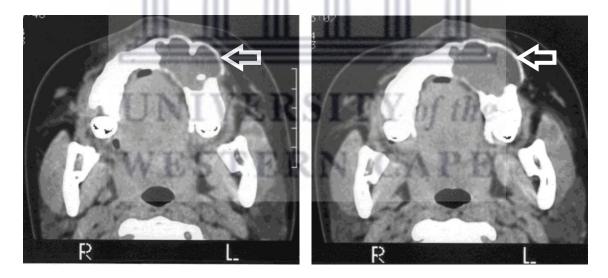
Axial CT images of same patient in Figure 4 showing scalloping of margins of the lesion mimicking an OKC.
